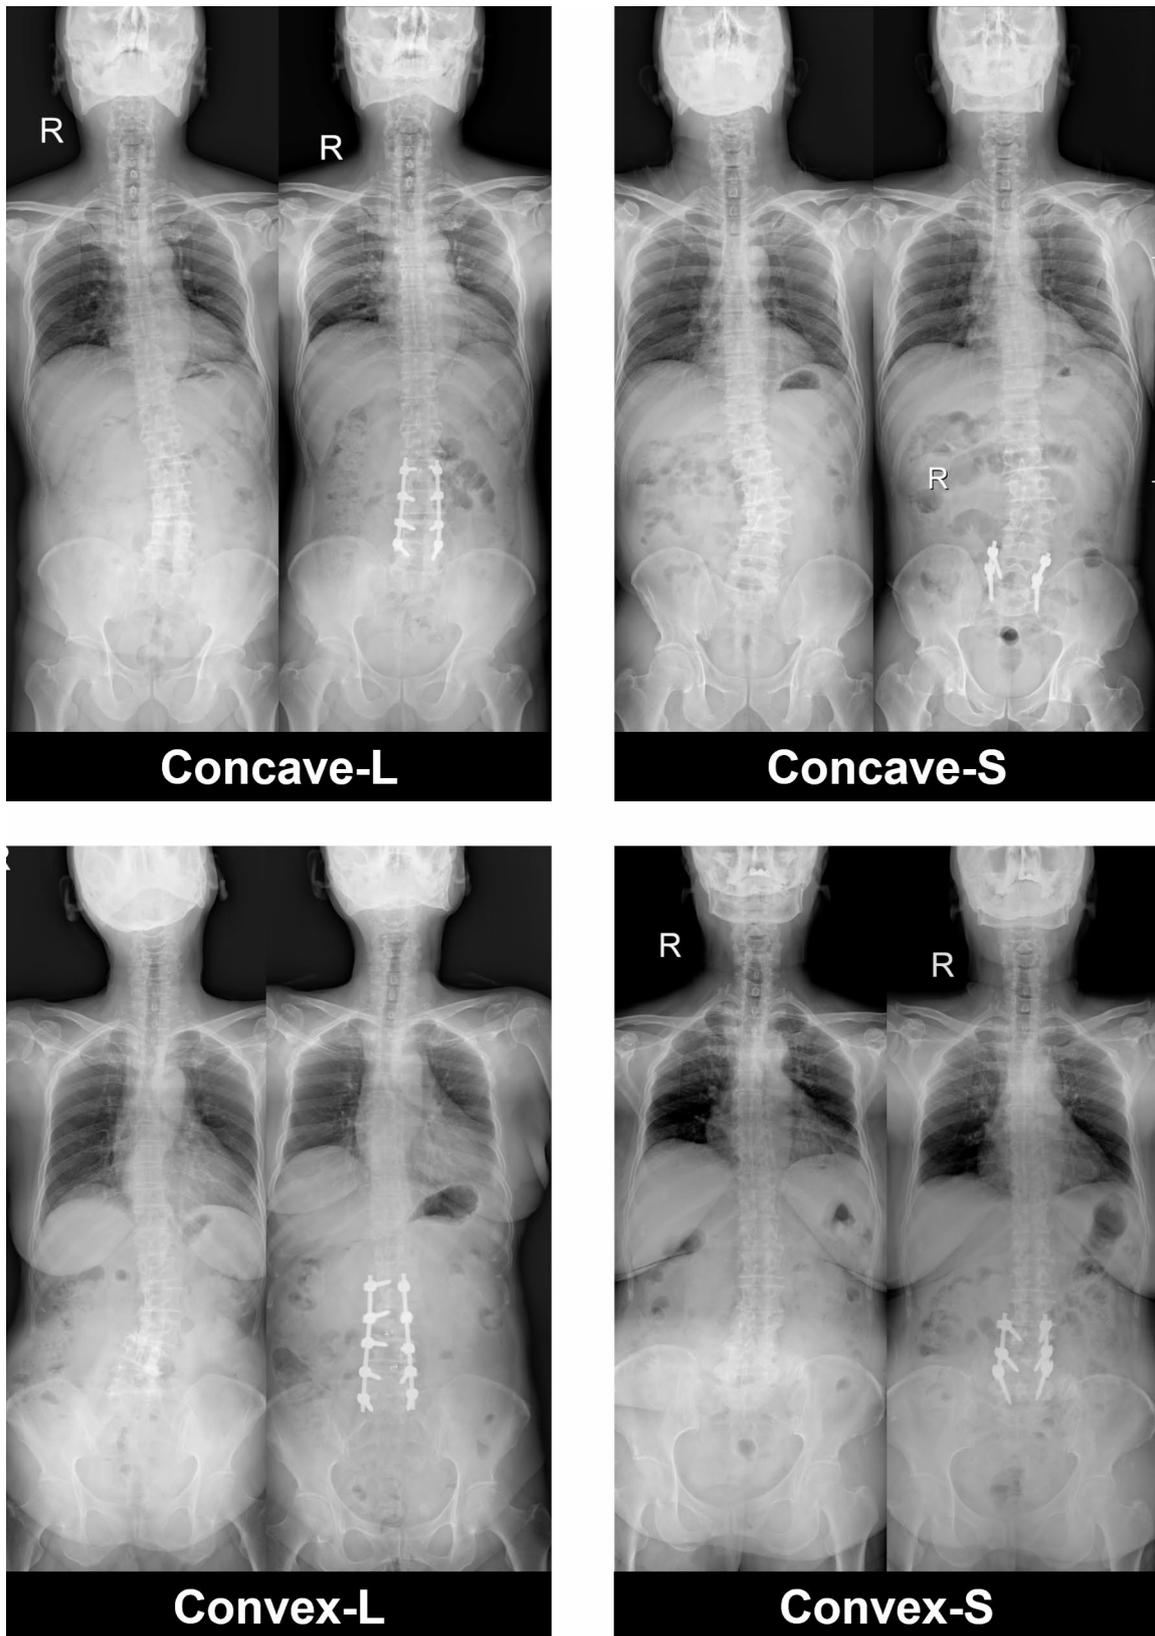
Anteroposterior X-ray images of the Concave-L, Concave-S, Convex-L, and Convex-S cases before and after surgery
